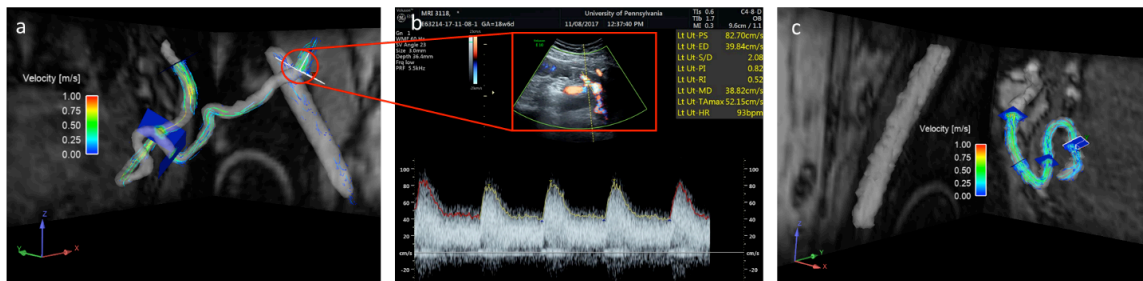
a) Example of healthy pregnant uterine artery 4D flow MRI pathlines, b) ultrasound of corresponding uterine artery with panel a, c) example of uterine artery 4D flow MRI in preeclamptic pregnancy
